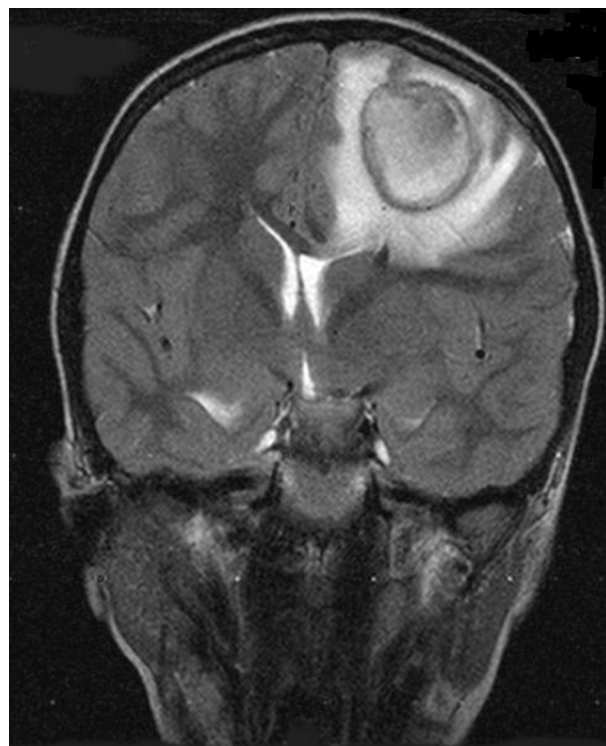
Coronal T2 flair magnetic resonance imaging showing the abscess in the left frontal lobe.
